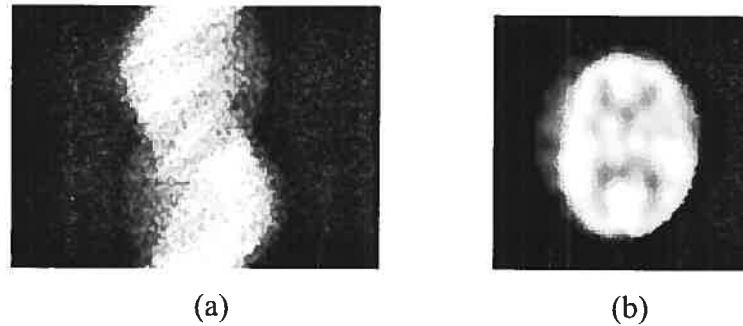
(a) The collection of Radon transforms of a brain slice at all angles. (b) A slice of a brain SPECT image.
